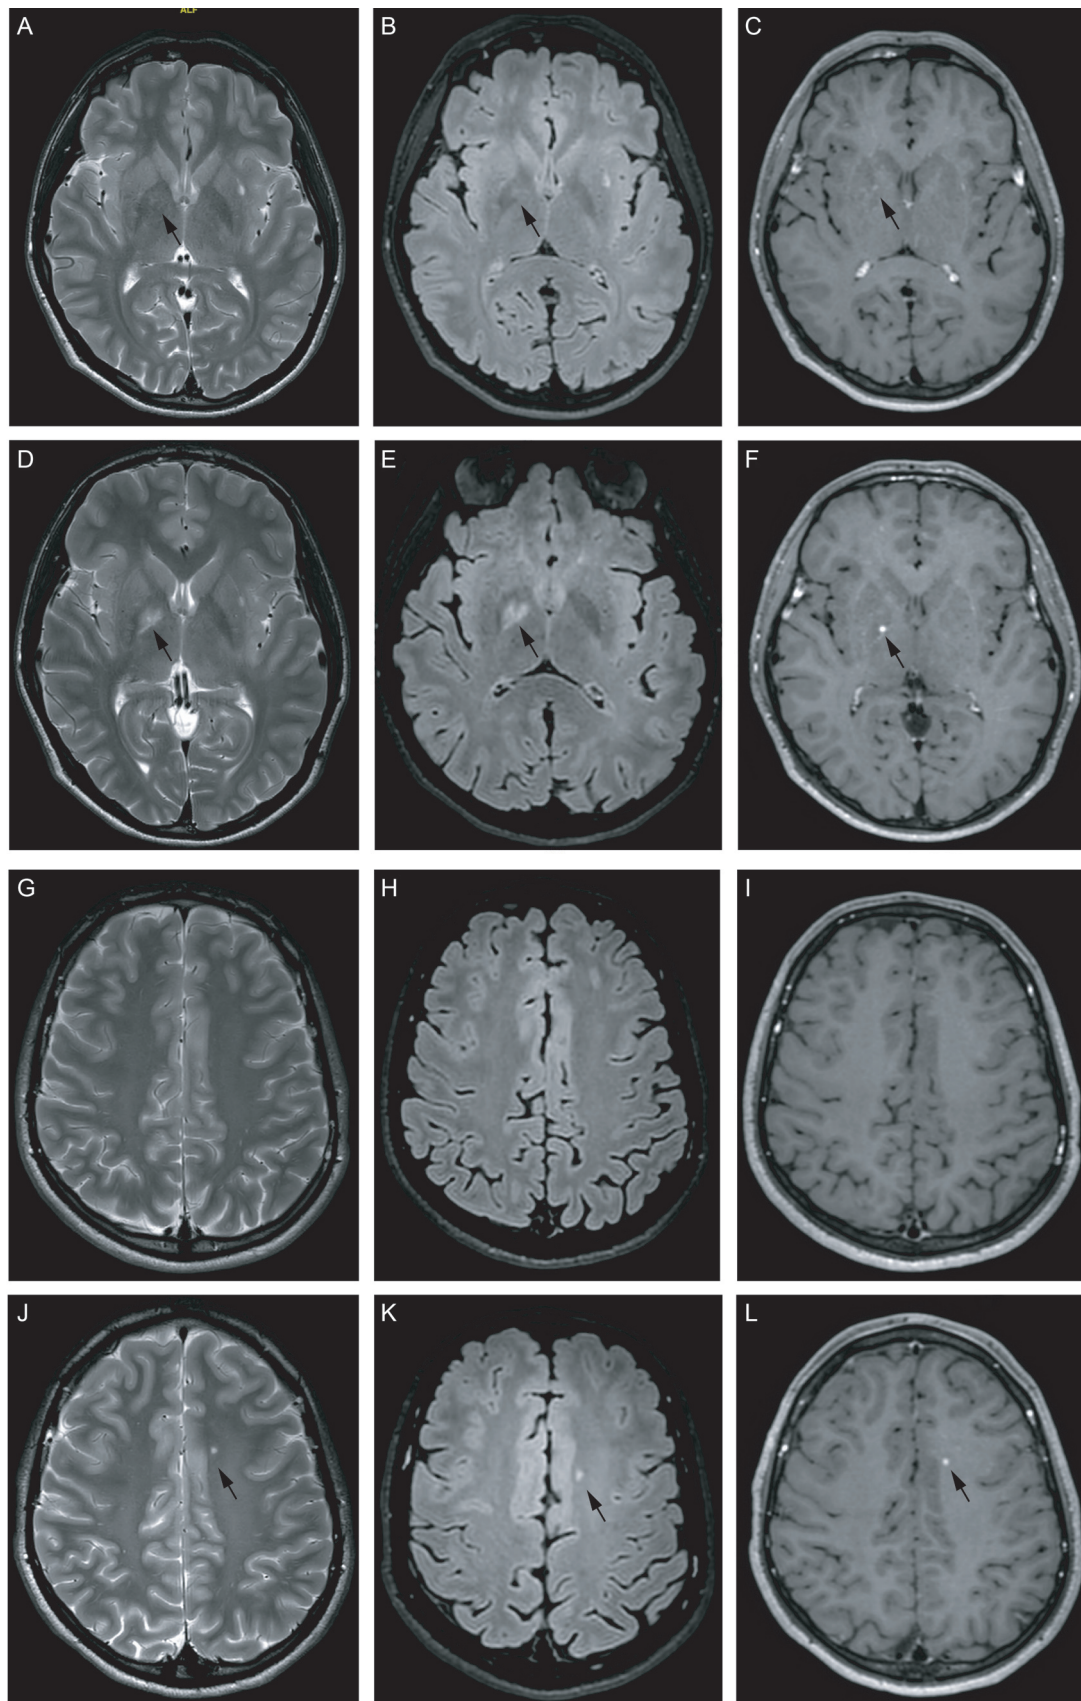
Repeated magnetic resonance imaging of patient 1 after 4 weeks. Comparison of MR images upon first admission (A–C; G–I) and after 4 weeks (D–F; J–L). In basal ganglia (A–F) increase in size of signal altered lesions with gadolinium enhancement. In white matter (G–L) occurrence of new signal altered lesions with gadolinium enhancement. Arrows point to lesions. T2-weighted imaging (A, D, G, J); fluid-attenuated inversion recovery imaging (B, E, H, K) and gadolinium-enhanced imaging (C, F, I, L). Arrows point to lesions.
